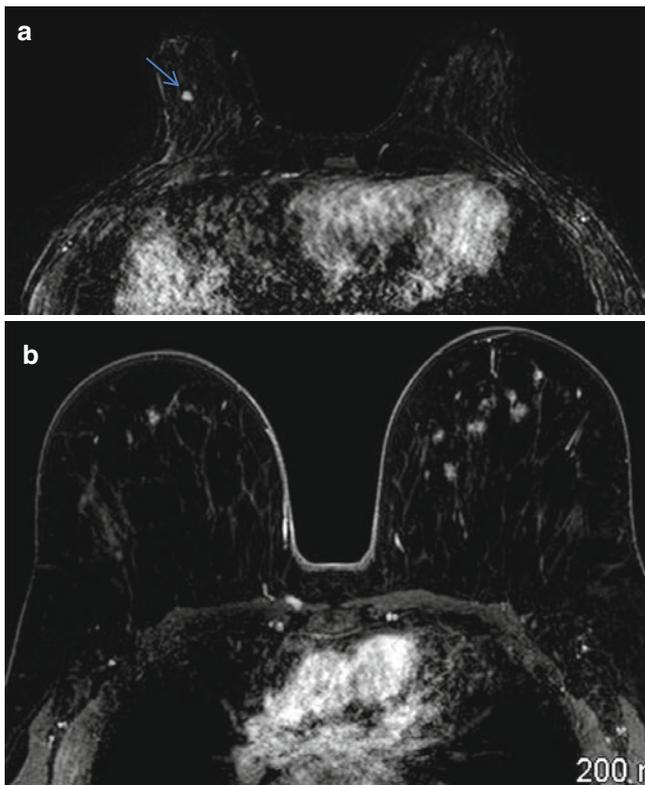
(a) Axial postcontrast fat-suppressed T1-weighted subtraction image shows a 4 mm enhancing focus in the right breast. (b) Axial postcontrast fat-suppressed T1-weighted subtraction image shows multiple bilateral enhancing foci
